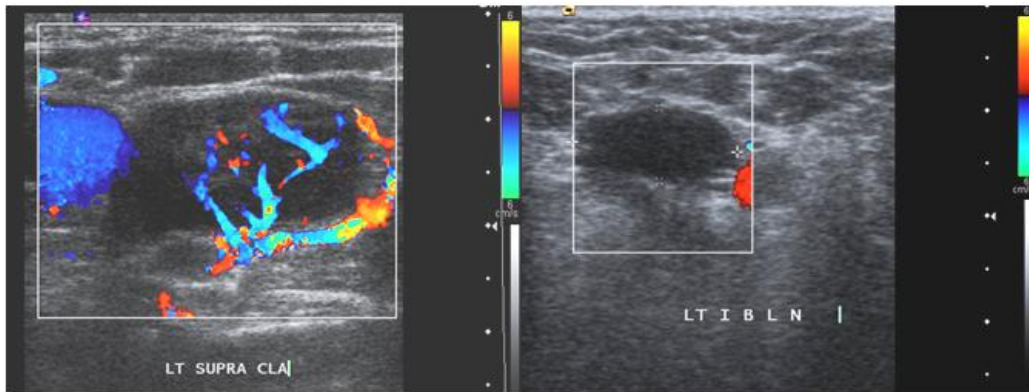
B &C. 51 Yrs old male patient with biopsy proven metastatic CA. (A) USG image showing heteroechoic, necrotic, matted right(RT) level IIA lymph nodes (arrow).(B&C) Color Doppler and Power Doppler show mixed vascularity.
